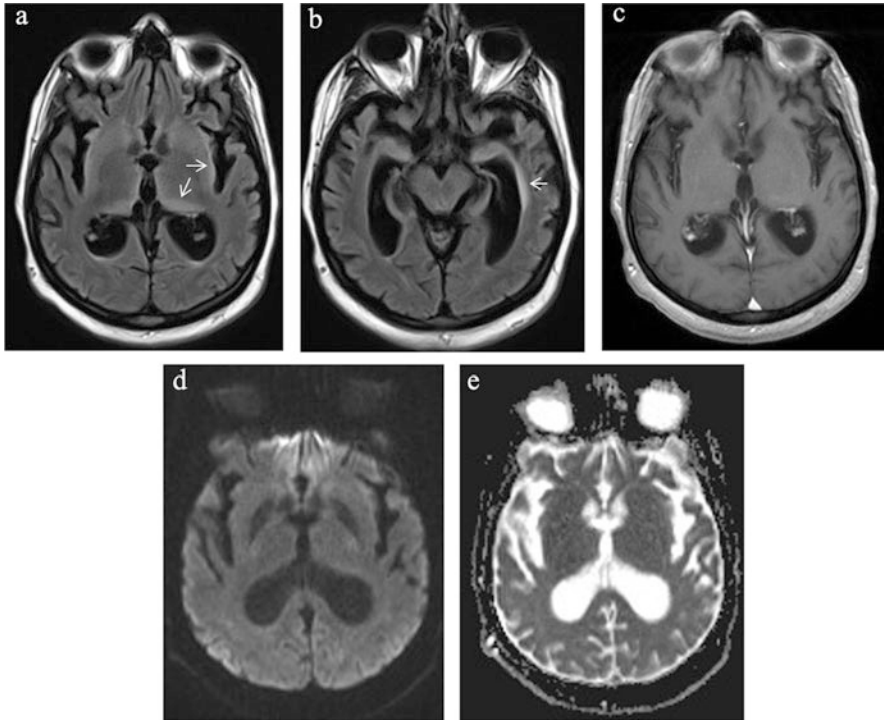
(a, b) Axial FLAIR images show an abnormal hyperintensities at bilateral Pulvinar, insular ribbon (a) and left periventricular WM (b) (white arrows), no corresponding enhancement (c), or diffusion restriction (d, e). *Image Source: Courtesy of King Abdulaziz Medical City- Western Region, Jeddah, KSA [Copyright Restrictions – NONE; this image is free of any copyright restrictions]*
